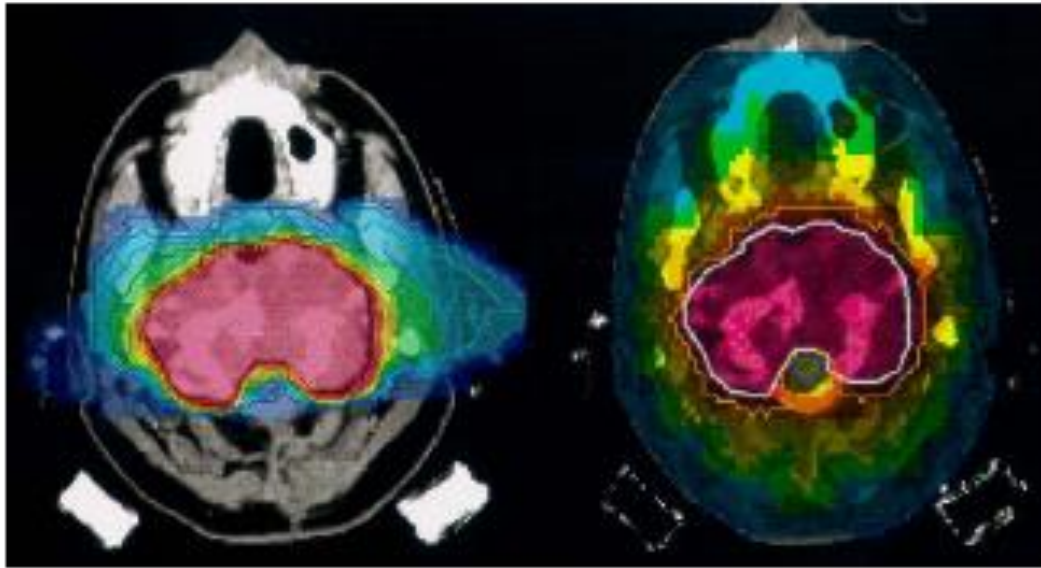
Comparison of treatment plans with 2 fields of carbon ion (IMPT—left panel) and with 9 fields of x-rays (IMRT—right panel) [23]. In both cases the conformity to the target volume is good but for carbon ions the dose to the normal tissues is much smaller.
